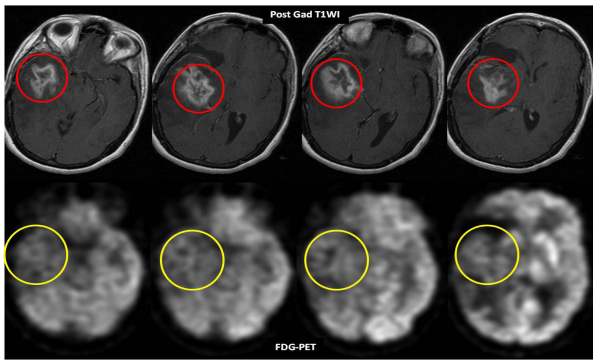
Panel of Axial Post-Contrast T1 MR Images (Top) and Corresponding FDG-PET Images (Bottom) Show Hypometabolism (Yellow Circle) in the Enhancing Lesion (Red Circle). This was a Case of Right Temporal Lobe High Grade Astrocytoma
